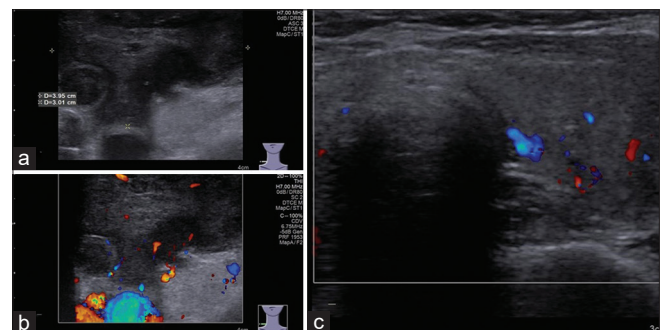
(a) The gray-scale ultrasonography shows no significant decrease of the tumor size (transverse diameters: $4.79 \text{ cm} \times 4.73 \text{ cm} \rightarrow 3.95 \text{ cm} \times 3.01 \text{ cm}$; $<25\%$ extent). (b) The color Doppler ultrasound shows reduction of twisted blood flow signals in the primary thyroid lymphoma after three cycles of rituximab plus bendamustine. (c) Color Doppler ultrasonographic image of the left thyroid gland is shown
